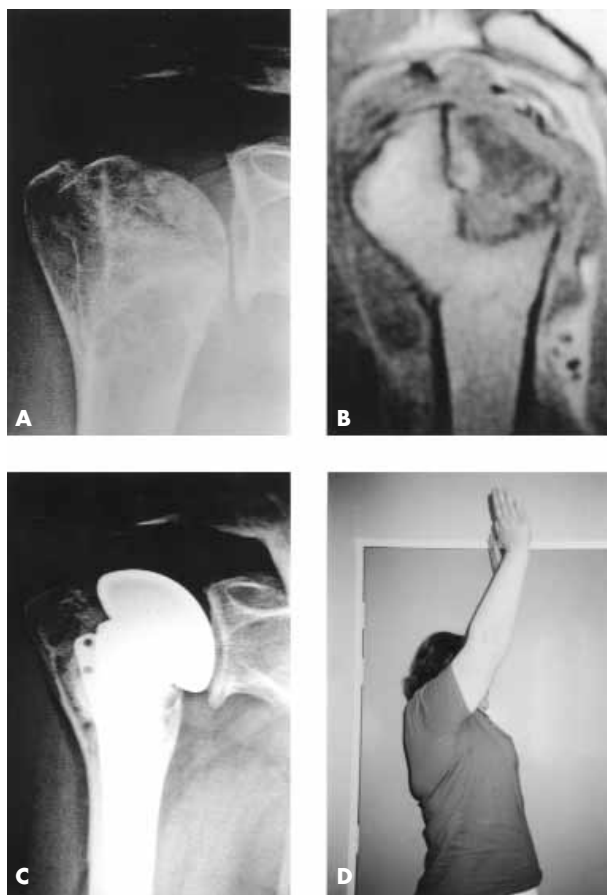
Radiograph (A) and MRI (B) of type 1 sequela of a proximal humerus fracture, with minimal displacement of greater tuberosity and impaction of head fragment (type 1). After shoulder arthroplasty (C), there was an excellent functional result (D), despite the slight distortion of the anatomy of the proximal humerus.
